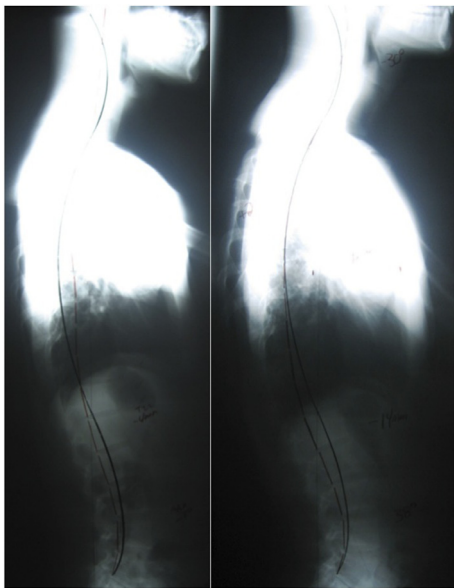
Lateral full spine radiography. Left: Initial view. Note straight back syndrome/thoracic hypokyphosis; Right: 12-week follow-up. Note the restoration of spinal curves. Red (dashed) line highlights patient posterior vertebral body positions; black line indicates normal/ideal alignment (CBP® Seminars, Inc.).
